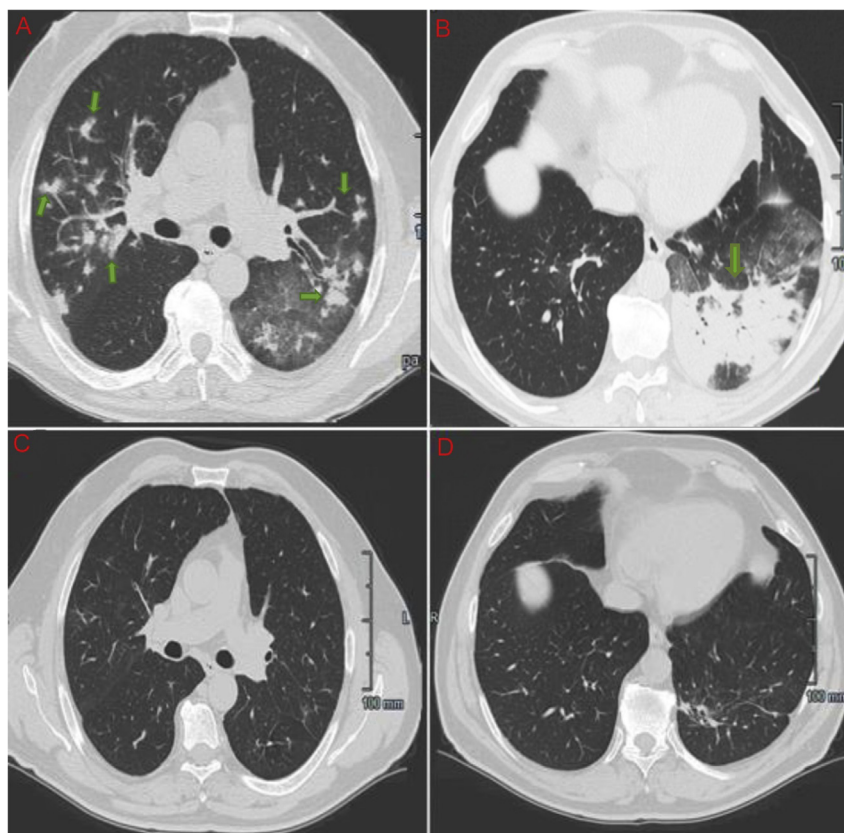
Computed Tomography Scan of the lungs. Multiple, solid masses with irregular margins, mediastinal lymphadenopathy, air bronchograms and ground-glass opacity, involving the upper lobes and the left lower lobe are evident. (A, B) (arrows) Follow-up Computed Tomography scan shows complete resolution of the lesions after three months of doxycycline treatment. (C, D).
